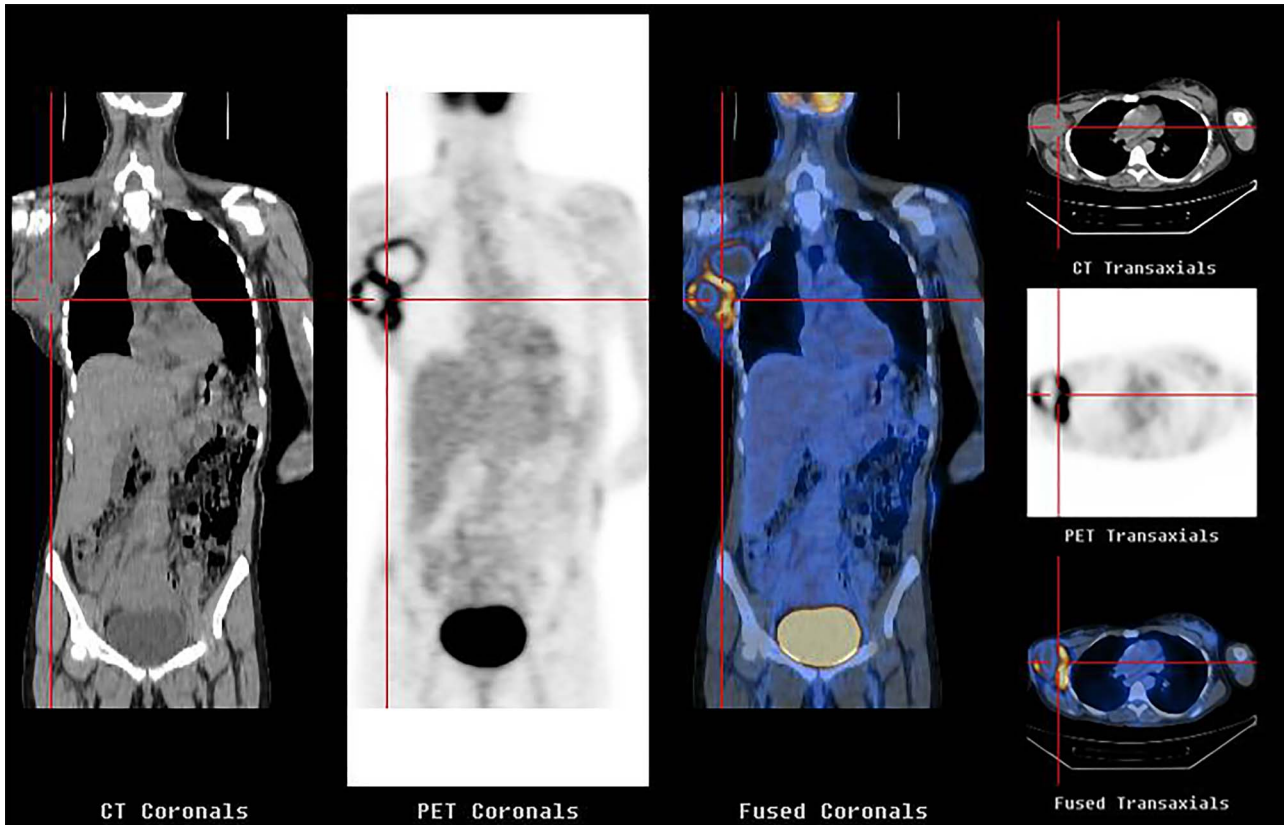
PET-CT with fluorodeoxyglucose showing a large hypercaptant lymph node conglomerate on the right axilla.
